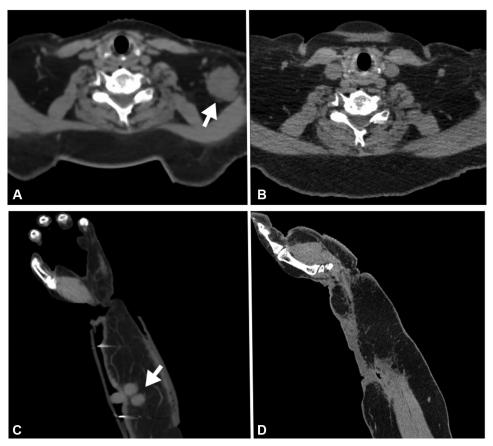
Pre- and post-treatment computed tomography (CT) imaging. A, Pre-treatment CT of the neck showing large left supraclavicular lymph node metastasis (*arrow*). B, Post-treatment CT of the neck. C, Pre-treatment CT of the left forearm showing cutaneous metastases on volar surface of forearm (*arrow*). D, Post-treatment CT of the left forearm.
